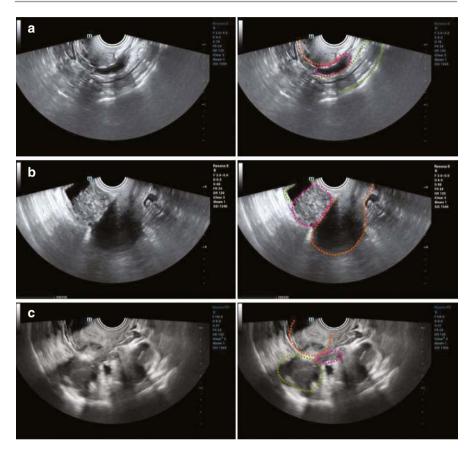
(a) B-mode ultrasound shows a hypoechoic nodule with irregular morphology on the anterior wall of the rectum. The cervix is outlined in orange; the rectum is marked in green; the DIE is circled in pink. (b) B-mode ultrasound shows DIE in the bladder, characterized by a heterogeneous hypoechoic mass within the bladder, with many tiny cystic changes. The uterus is circled in orange; the bladder is marked in green; the DIE is circled in pink. (c) A hypoechoic nodule is visualized at the beginning of the left uterosacral ligament, which adheres to the right ovary. The cervix is circled in orange; the right ovary is circled in green; the DIE nodule is circled in pink
